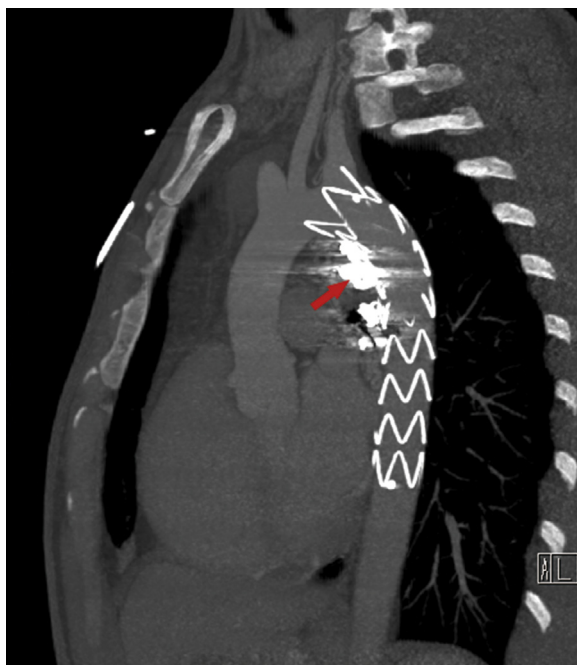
Four-month follow-up CT angiography showed that the stent-graft remained in its proper position without an endoleak in the bronchial artery aneurysms (arrow).
